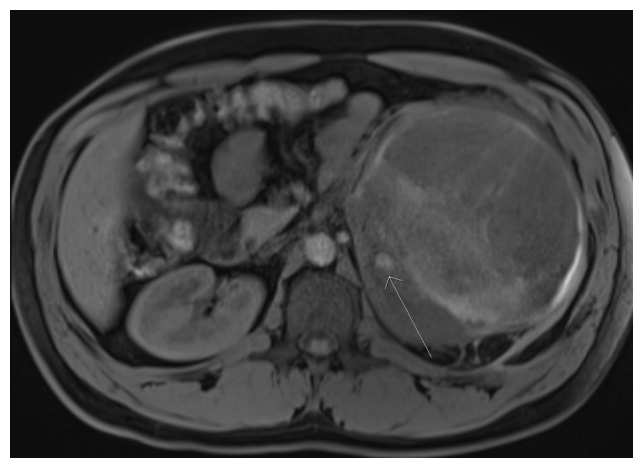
Axial view of an MRI abdomen with an arrow pointing the calcified lesion of interest in the lower pole of the right kidney.
